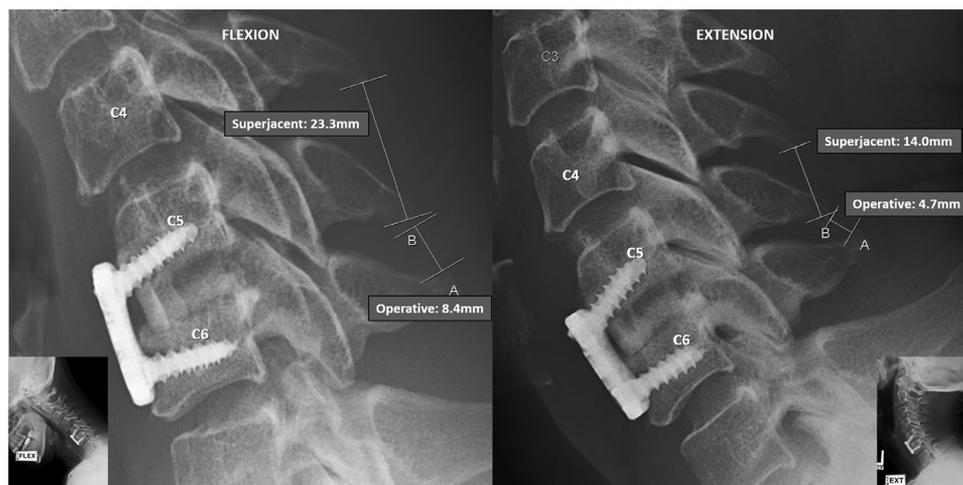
Cervical pseudarthrosis on dynamic x-rays as described by Riew *et al.* Flexion and extension cervical radiographs are magnified to 150% on the same monitor, and the interspinous motion of the superjacent level (C4-5) was measured and found to be 9.3 mm (23.3 mm – 14 mm), indicating adequate dynamic x-rays had been obtained (i.e. >4 mm of motion). The interspinous motion at the operative level (C5-6) was found to be greater than the 1 mm cutoff at 3.7 mm (8.4 mm – 4.7 mm), indicating excessive motion at the fusion site, consistent with a pseudarthrosis.
